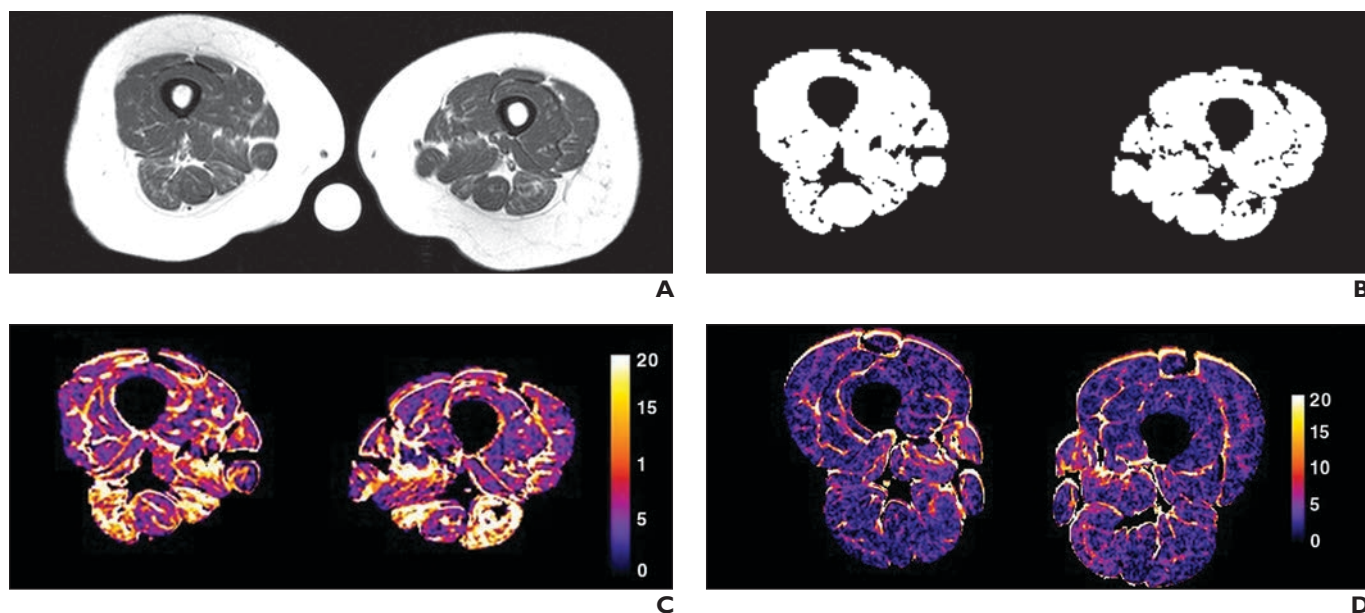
Use of MRI to measure muscle and fat-water separation in two different patients. (Courtesy of Rider L)
